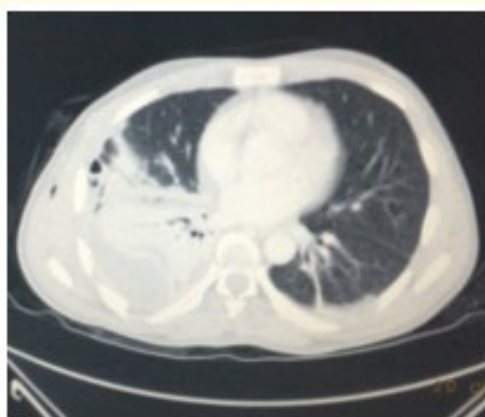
Thoracic CT scan findings on seventh day: multi-loculated pleural effusion in the right pleural cavity.
